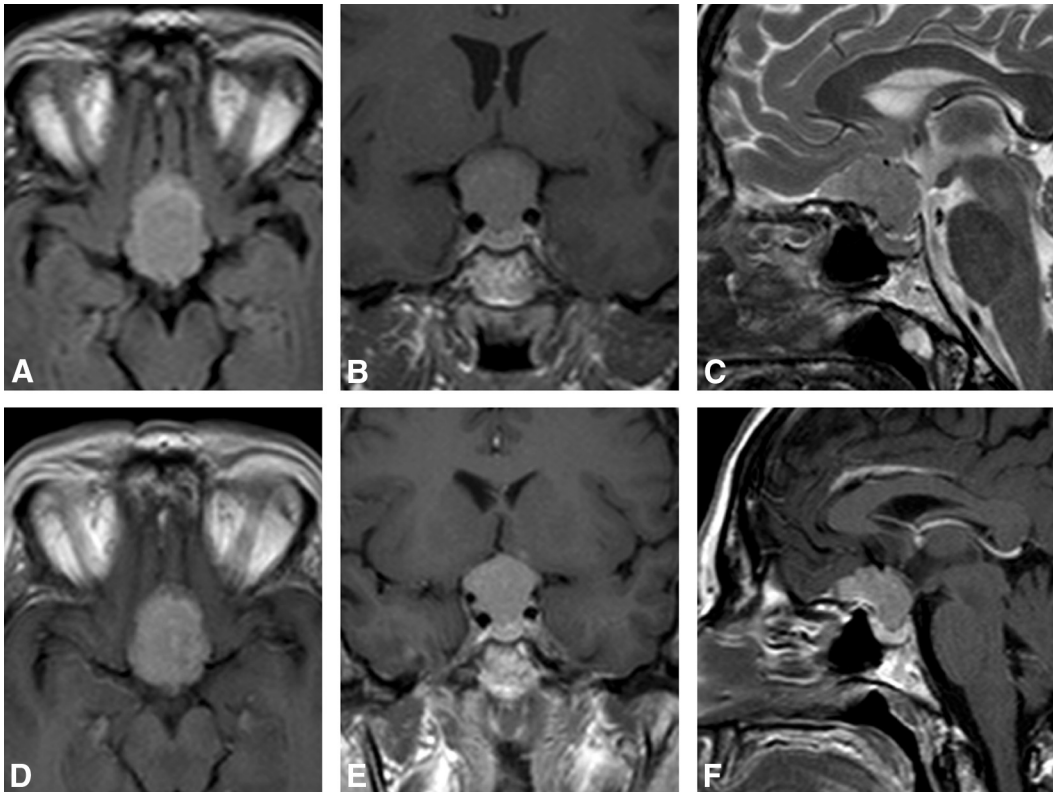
Planum sphenoidale meningioma. Axial T2 FLAIR (A); coronal T1WI (B); sagittal T2WI (C); and axial (D), coronal (E), and sagittal (F) postgadolinium T1WI of a planum sphenoidale meningioma. A 37-year-old man with headache and bitemporal hemianopia. The MR imaging shows a lesion centered on the planum sphenoidale, with compression of the pituitary gland and displacement of the optic chiasm.
